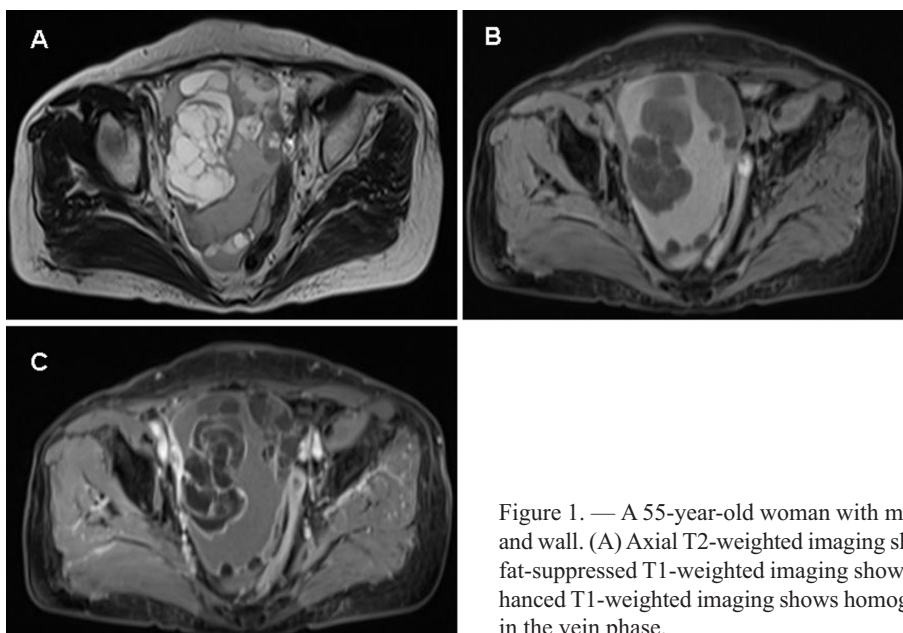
A 55-year-old woman with mucinous cystadenoma with regular shape and wall. (A) Axial T2-weighted imaging shows high homogeneous signal. (B) Axial fat-suppressed T1-weighted imaging shows low homogeneous signal. (C) Axial enhanced T1-weighted imaging shows homogeneous enhancement on the wall of mass in the vein phase.
